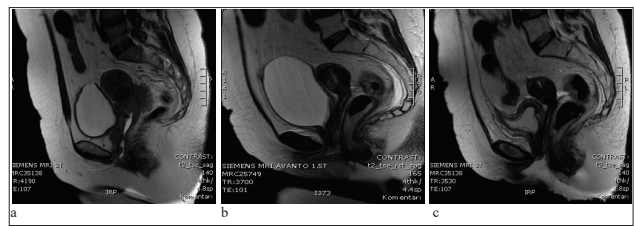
MRI-T2 sag: Regression of cervical carcinoma FIGO III B: a. before, b. after, c. a year after radio/chemo treatment
